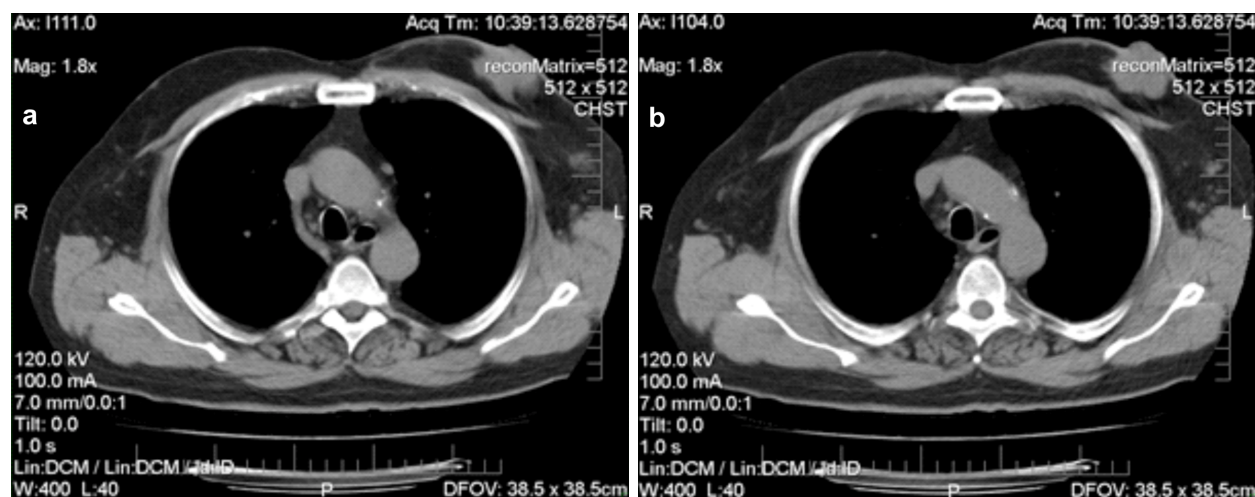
(a and b) Computed tomography of thorax: large breast tumor that infiltrates the skin and pectoral muscle; in the axilla, there are enlarged lymph nodes.
